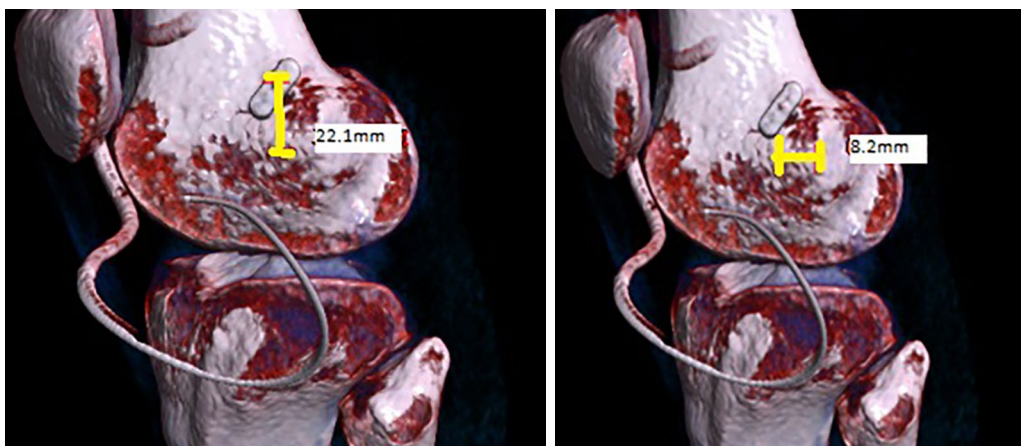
3D CT reconstruction showing measurement of the superior distance and anterior distance of the femoral tunnel exit from the lateral epicondyle.
